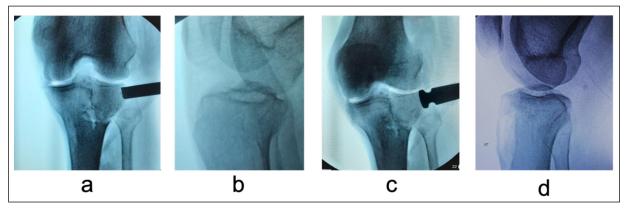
a, Joint radiograph taken with 3 mm joint step-off. b, Lateral knee radiograph taken with 3 mm joint step-off. c, Joint radiograph taken with 5 mm joint step-off. d, Lateral knee radiograph taken with 5 mm joint step-off.
